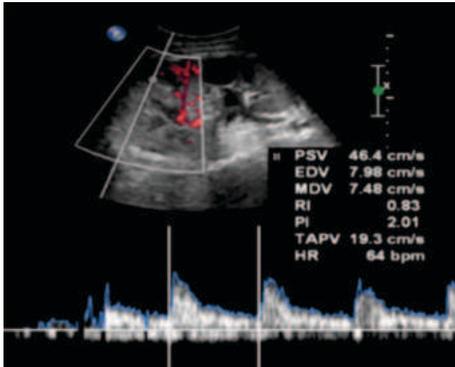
Case 2: On Color Doppler Examination of Right Kidney, Renal RI Appears Increased Measures 0.83
